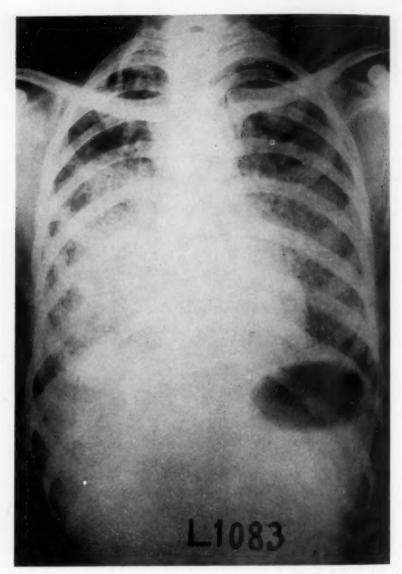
Case 2. Chest roentgenogram reveals a diffuse mottling throughout both lungs, most dense in the hilar areas and radiating well out into the periphery.
